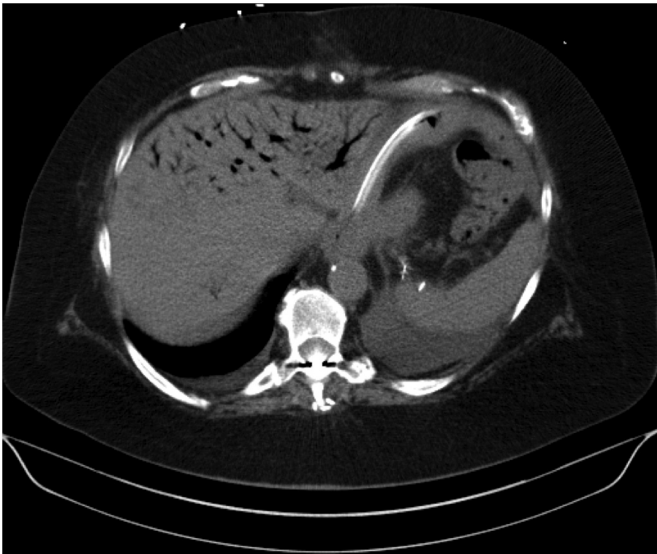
Axial view of abdominal/pelvic CT scan showing extensive hepatic portal venous gas and pneumatosis intestinalis.
